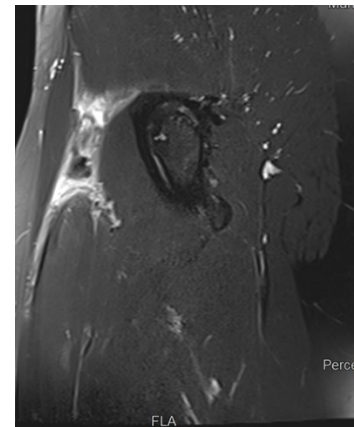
MRI pelvis, sagittal cuts showed avulsion of right rectus femoris.
